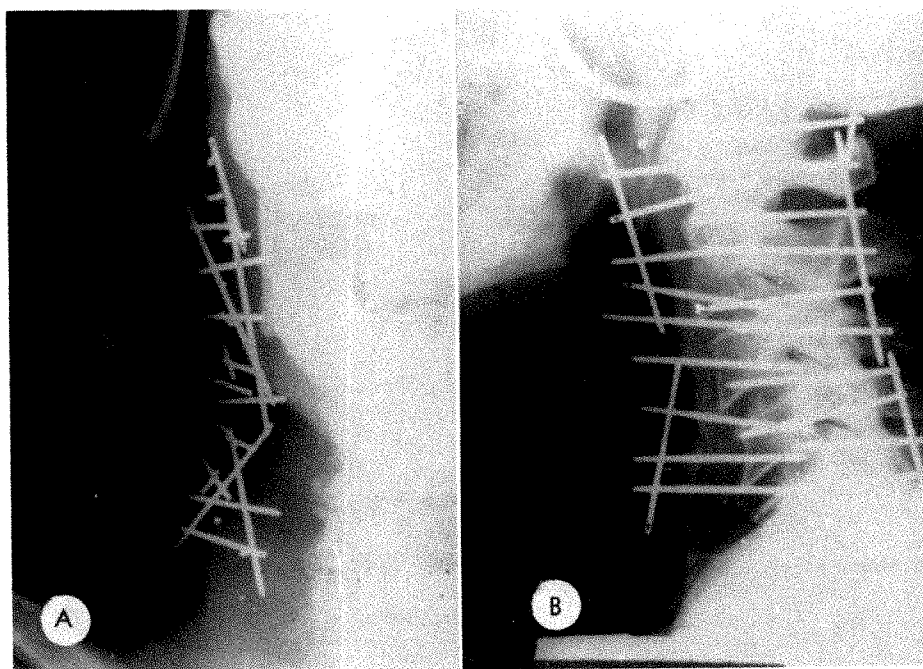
L.B. 65 W M. Carcinoma, cylindromatous pattern, involving the right side of the neck in the upper carotid region from the tail of the parotid gland. The patient came for therapy after a local excision of the tumor mass was performed. It was decided to use combined 220 kv. roentgen therapy and radium implantation, starting with single field external beam therapy.
